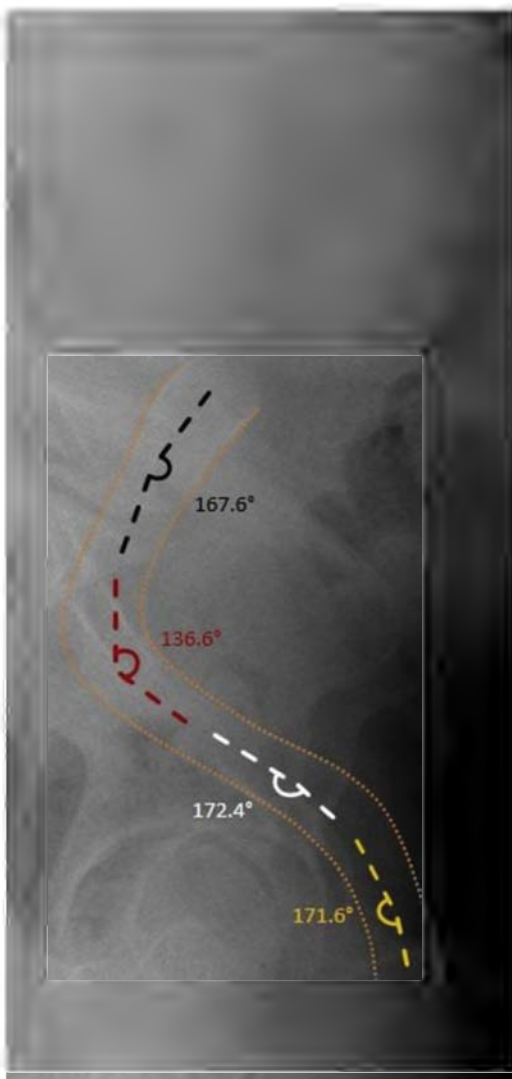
Lateral view radiograph demonstrating the tortuosity of the femoroiliacal segment with depiction of angulation at multiple points following deployment of a self-expanding woven stent (Wallstent).
